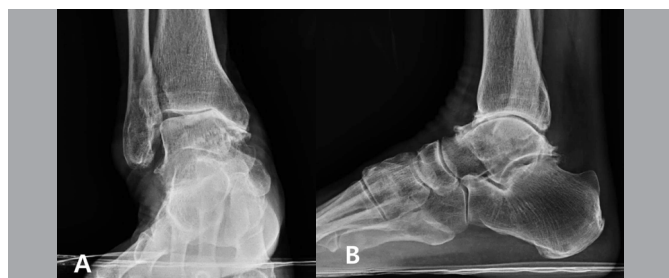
Plain radiographs showing end-stage arthritis in the ankle joint through anteroposterior (AP) view (A) and lateral view (B).
